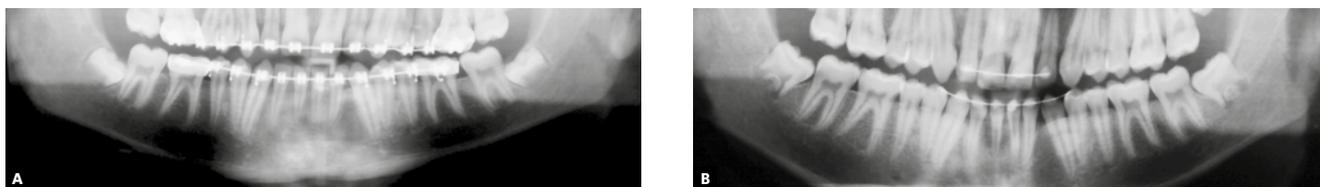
Panoramic radiograph after orthodontic treatment of the patient #6 at: A) 14 years and 9 months of age (PR1) and B) 16 years and 7 months (PR2). When examining the PR1, 64.7% of orthodontists and 29.4% of OMFS indicated the extraction of left M3M, while 64.7% of orthodontists and 35.3% of OMFS indicated the extraction of right M3M. By examining the two radiographs (PR1+2), 23.5% of orthodontists and 76.4% of OMFS indicated the extraction of the left M3M, while 17.6% of orthodontists and 70.6% of OMFS indicated extraction of the right M3M.
